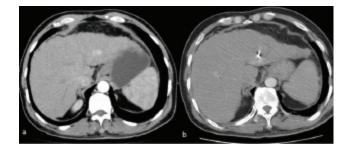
Another male patient with lesion in left lobe of liver (a) RFA performed under CT guidance (b) Needle can be seen.
